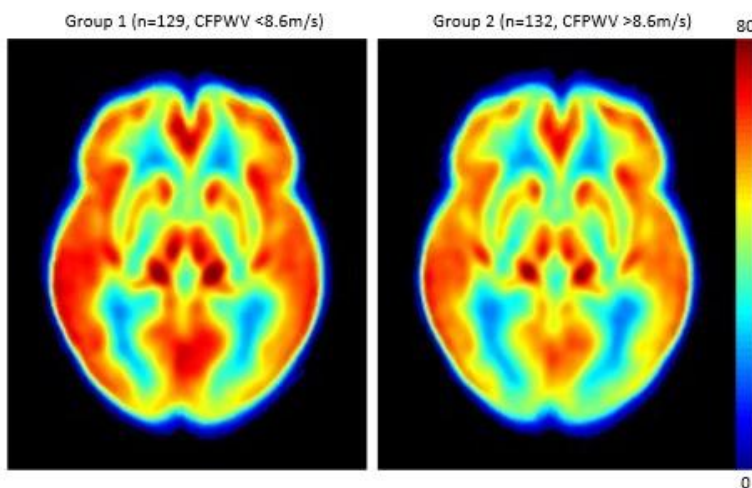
Average total brain perfusion map split by median CFPWV (8.6 m/s) measured by ASL MRI in Paper III.
